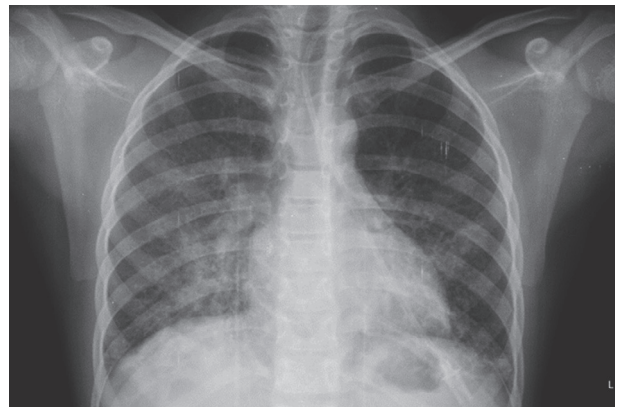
Chest radiograph that shows a right lower lobe infiltrate.
